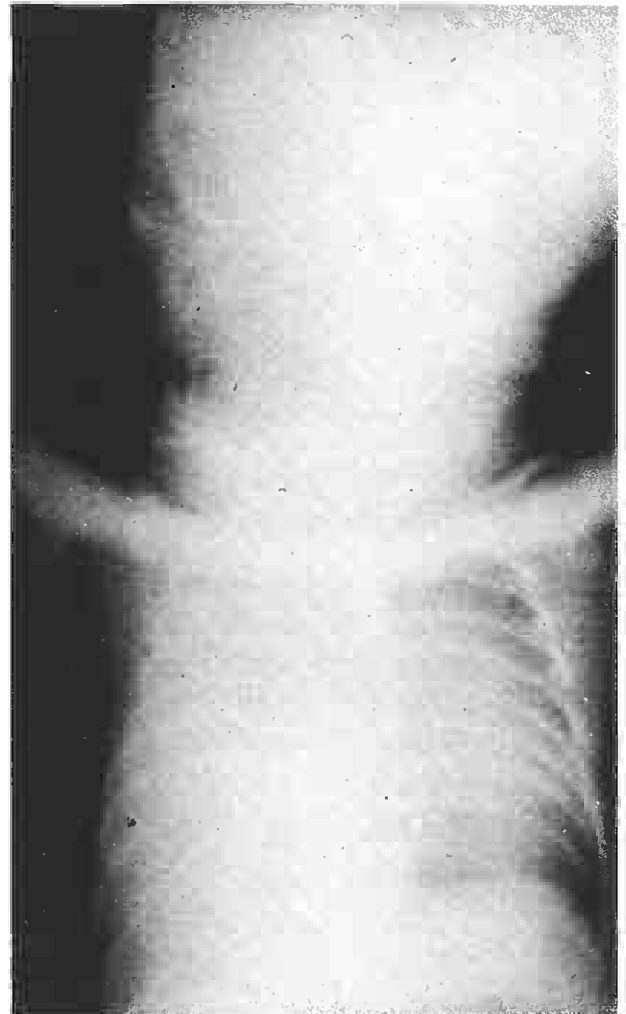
X-ray film showing opacification of the right hemithorax and displacement of the mediastinum to the left.
